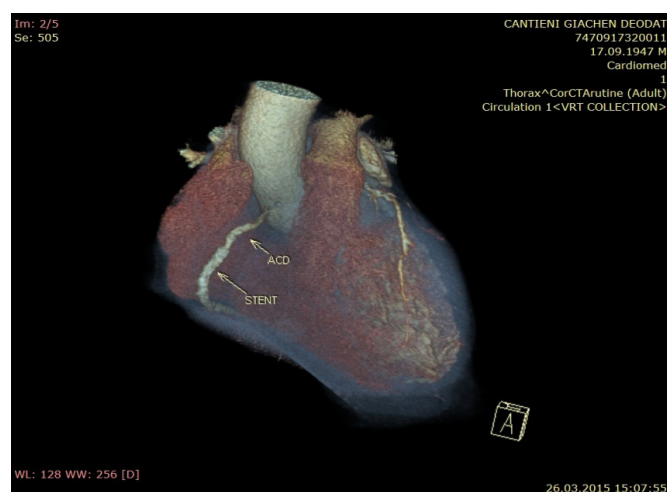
Angio CT Multislice showing patent right coronary artery
